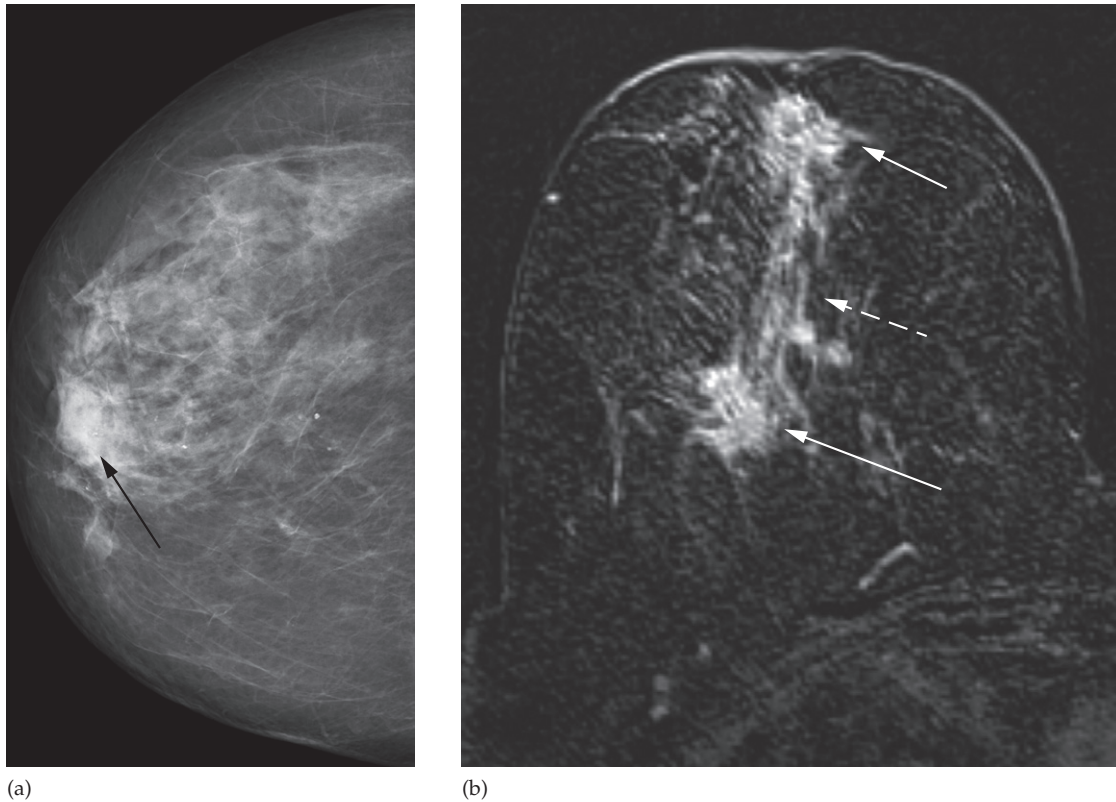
Breast cancer with ductal carcinoma in situ. (a) Mammography demonstrates an irregular malignant mass (black arrow) with some associated microcalcification. (b) Axial contrast-enhanced subtracted MRI reveals the enhancing index mass (short arrow) and an additional unsuspected malignancy posteriorly (long arrow) with intervening linear and nodular enhancement typical of ductal carcinoma in situ (dashed arrow).
